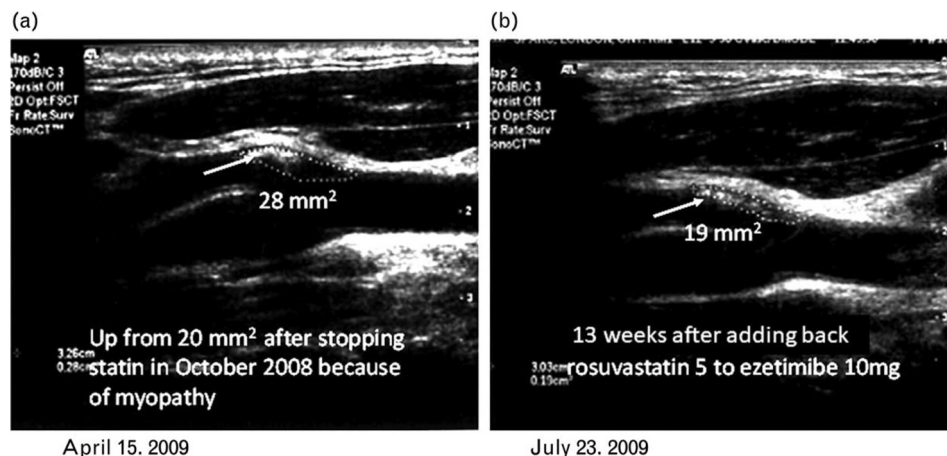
Plaque regression and change in plaque composition occur much faster than most practitioners would expect. (A) Soft plaque at the origin of the left external carotid in a 64-year-old man using ezetimibe alone because of myalgia and cramps with statins. His plaque (*white arrow*) had progressed from 20 mm² 6 months earlier to 28 mm² after stopping rosuvastatin and taking ezetimibe alone. After restarting rosuvastatin 5 mg daily with ezetimibe 10 mg daily, the plaque area regressed to 19 mm² over 13 weeks (B). The plaque had also become denser, with regression of the echolucent portion of the plaque. The echolucent portion of the plaque in panel A was outlined using Doppler color flow around it, as is done with juxtaluminal black plaque. Reproduced with permission from Elsevier from reference 6. The subject granted permission for use of these images and their identifying data, including all dates.
